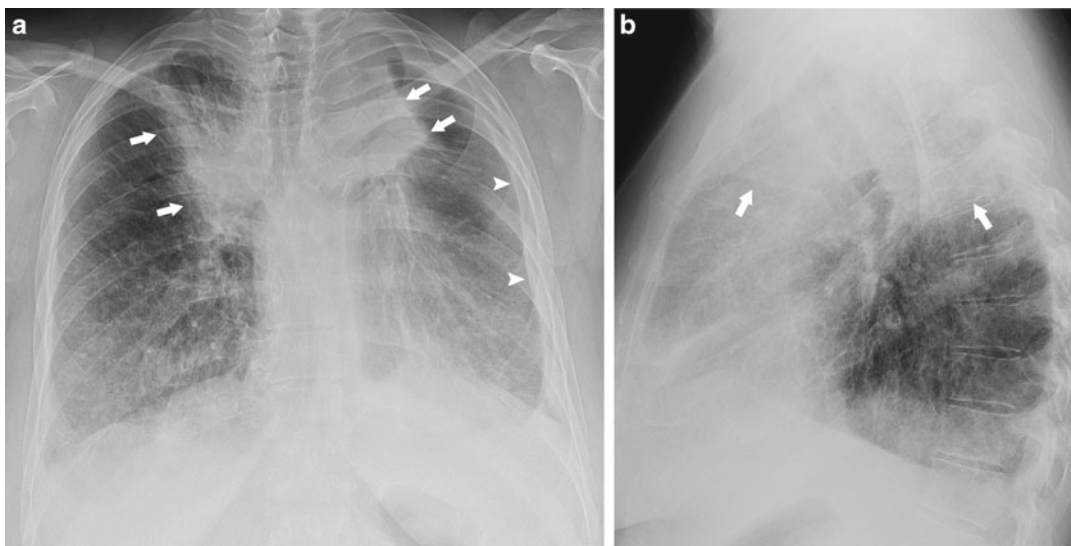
Bilateral radiation fibrosis. (a) PA chest radiograph shows extensive bilateral fibrosis with sharp lateral margins (arrows). Traction from this lung fibrosis has
